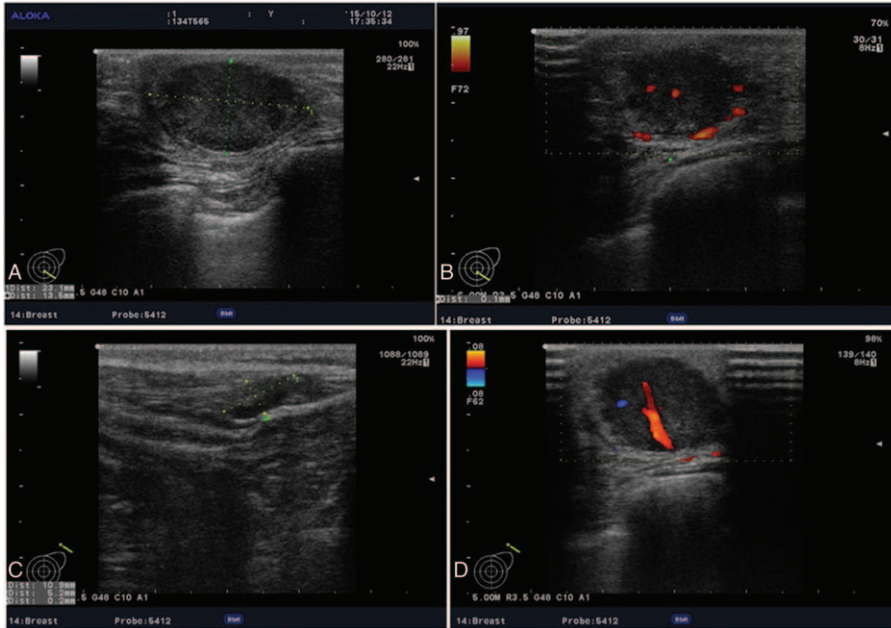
Ultrasound showed a 23-mm × 14-mm nodular low echo in the outer lower quadrant of the left breast with a non-uniform texture and a well-defined boundary. Color Doppler flow images displayed blood flow. Multiple axillary lymph nodes were identified; the largest measuring 11 mm × 5 mm.
